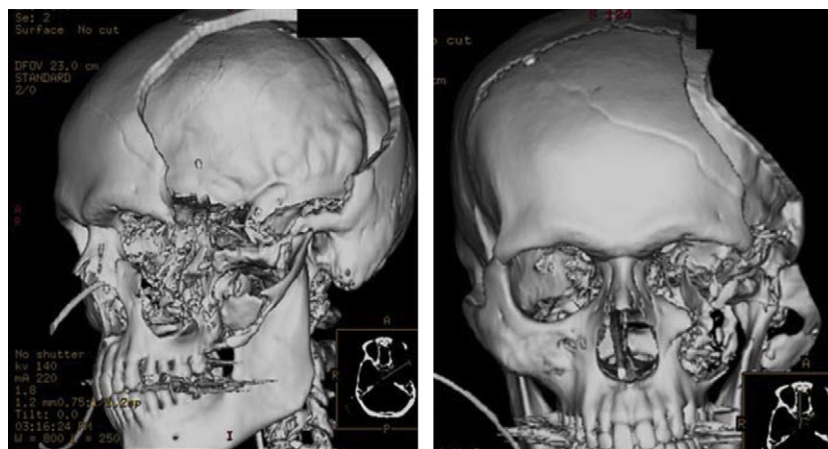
Three-dimensional bony CT reconstruction of the patient in Fig. 8 following his operative procedure. Note the severe bony disruption of the lateral orbital wall, maxilla, and temporal fossa. These bony defects require extensive reconstruction and are best managed in a delayed fashion.
